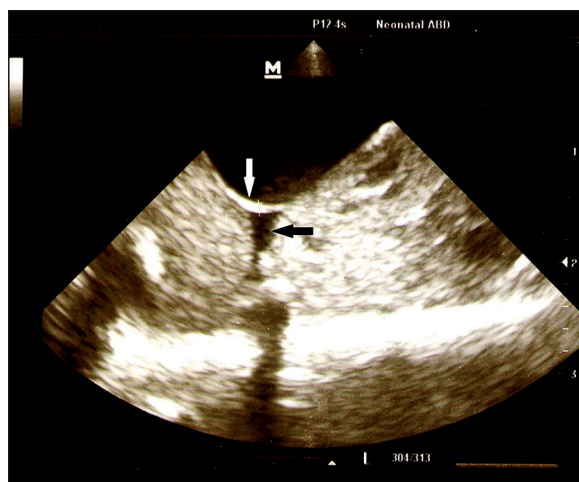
Sonogram of a 27-week old boy suspected to NEC. A dilated bowel loop with increased bowel wall echogenicity (white arrow) is seen, indicative of intra-mural air. Echoic free fluid also is seen adjacent to affected bowel loop (black arrow).
